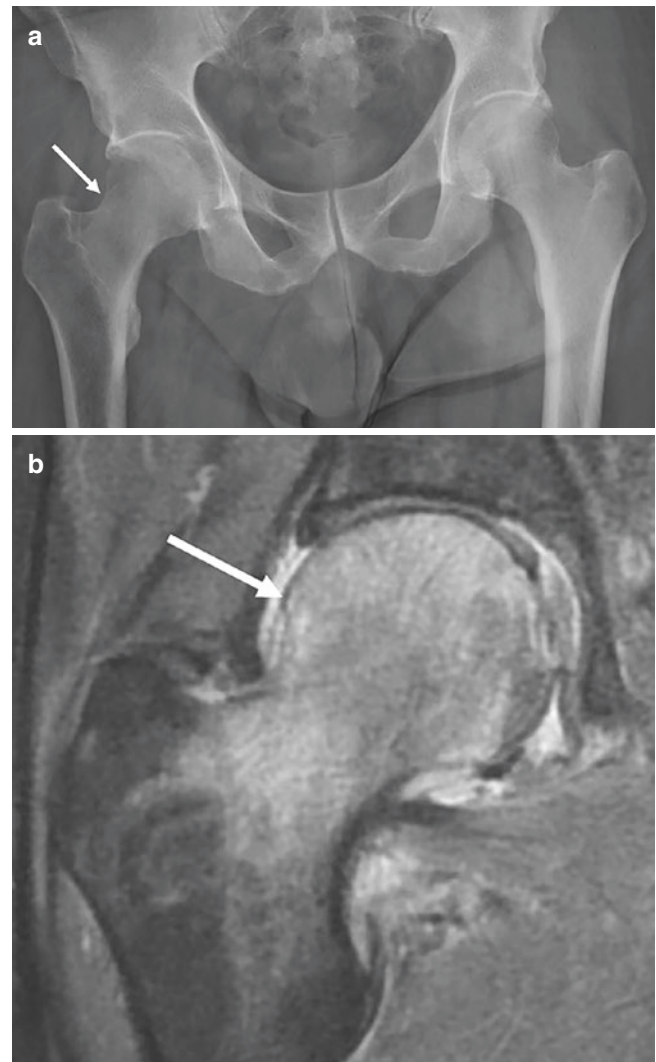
Anteroposterior radiograph (a) of the pelvis in a 52-year-old man shows lucency of the right femoral head/neck (arrow). Coronal T2 fat-suppressed MR image (b) shows diffuse bone marrow edema within the femoral head/neck (arrow). There is no subchondral fracture line or findings of osteonecrosis
